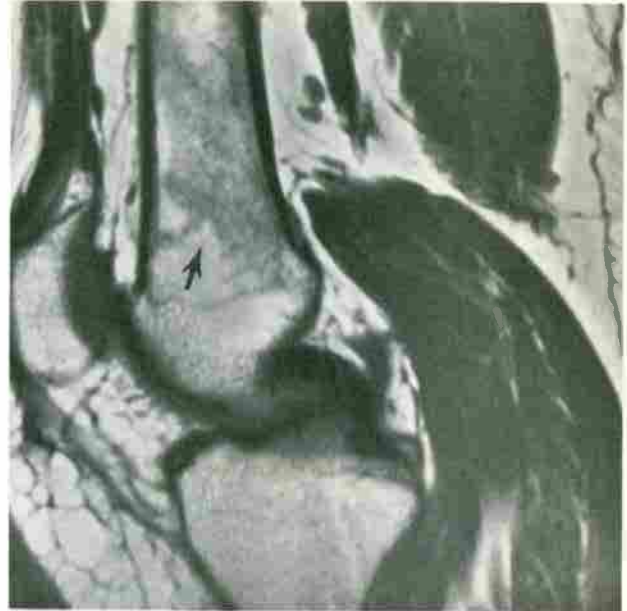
Medullary infarcts. A, Axial and (B) coronal T1-weighted (TR/TE, 500, 700/20) images. This 16 year old with Hodgkin's disease developed knee pain after bone marrow transplant. Characteristic appearance of metaphyseal and epiphyseal infarcts with low-signal-intensity serpiginous margins (arrows).
